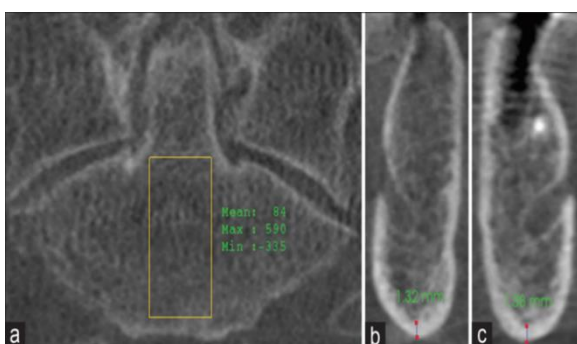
CBCT scan of a patient at high risk of osteoporosis; (a)
